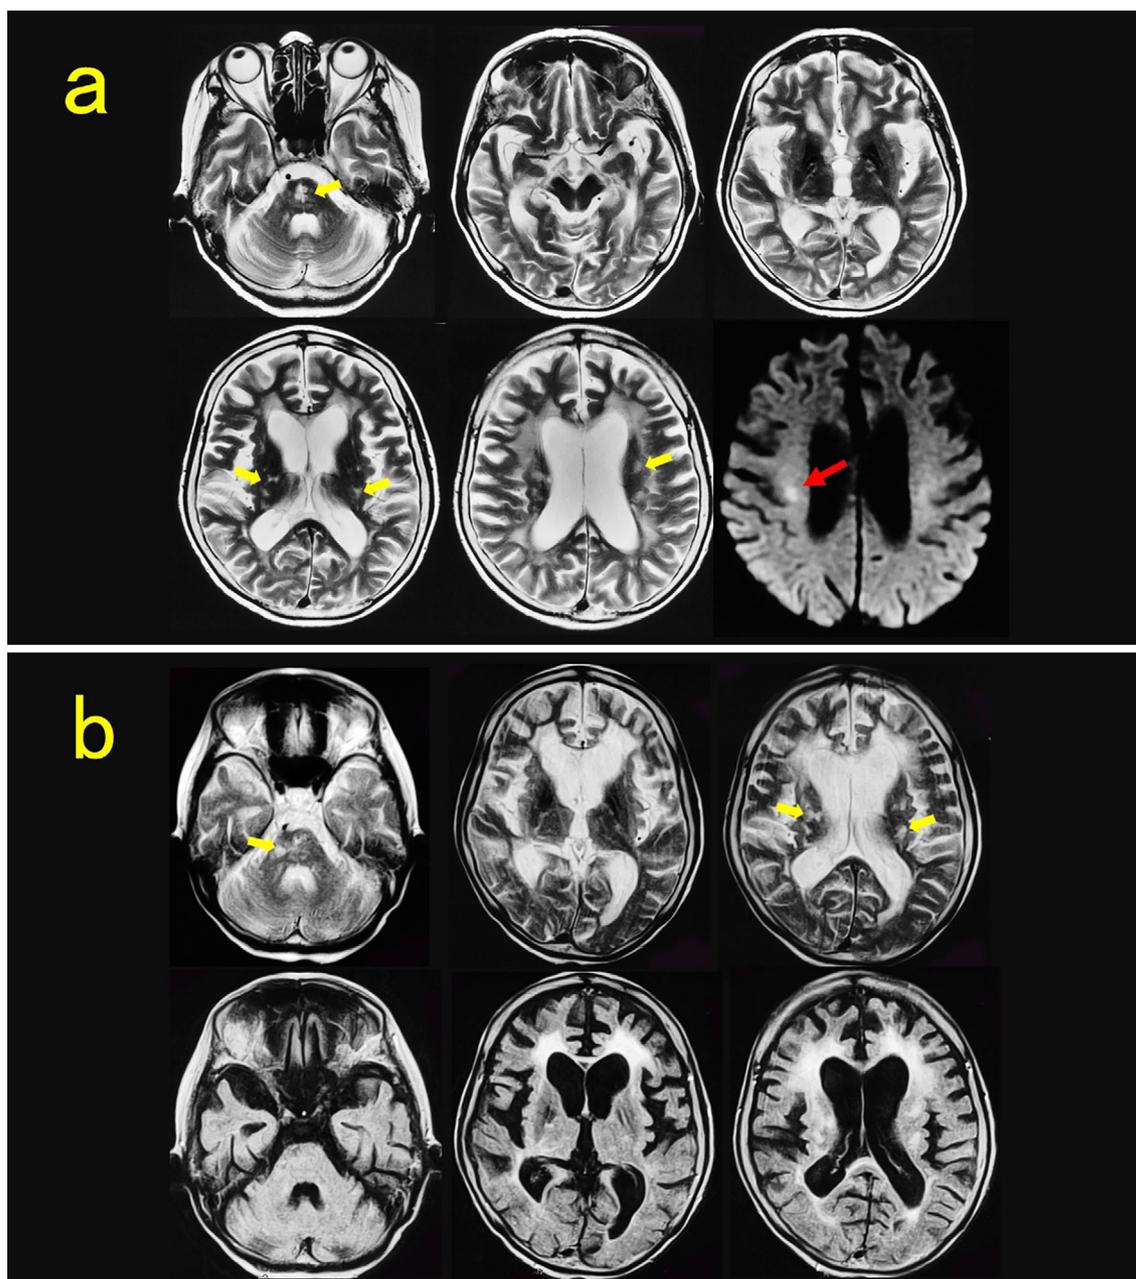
MRI of the head. (a) At 69 years old. Small multiple irregular plaques were found in the pons and periventricular area (T2 and DWI) (yellow arrow). A new lesion was also found on DWI (red arrow). (b) At 70 years old. Progressed white matter lesions accompanied by cerebral atrophy and ventricular dilatation were shown (T2 and FLAIR) (yellow arrow).
